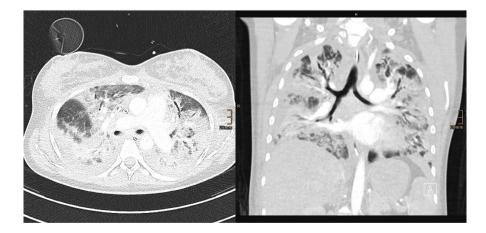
CT scan of the maternal lungs at the time of listing for transplantation
